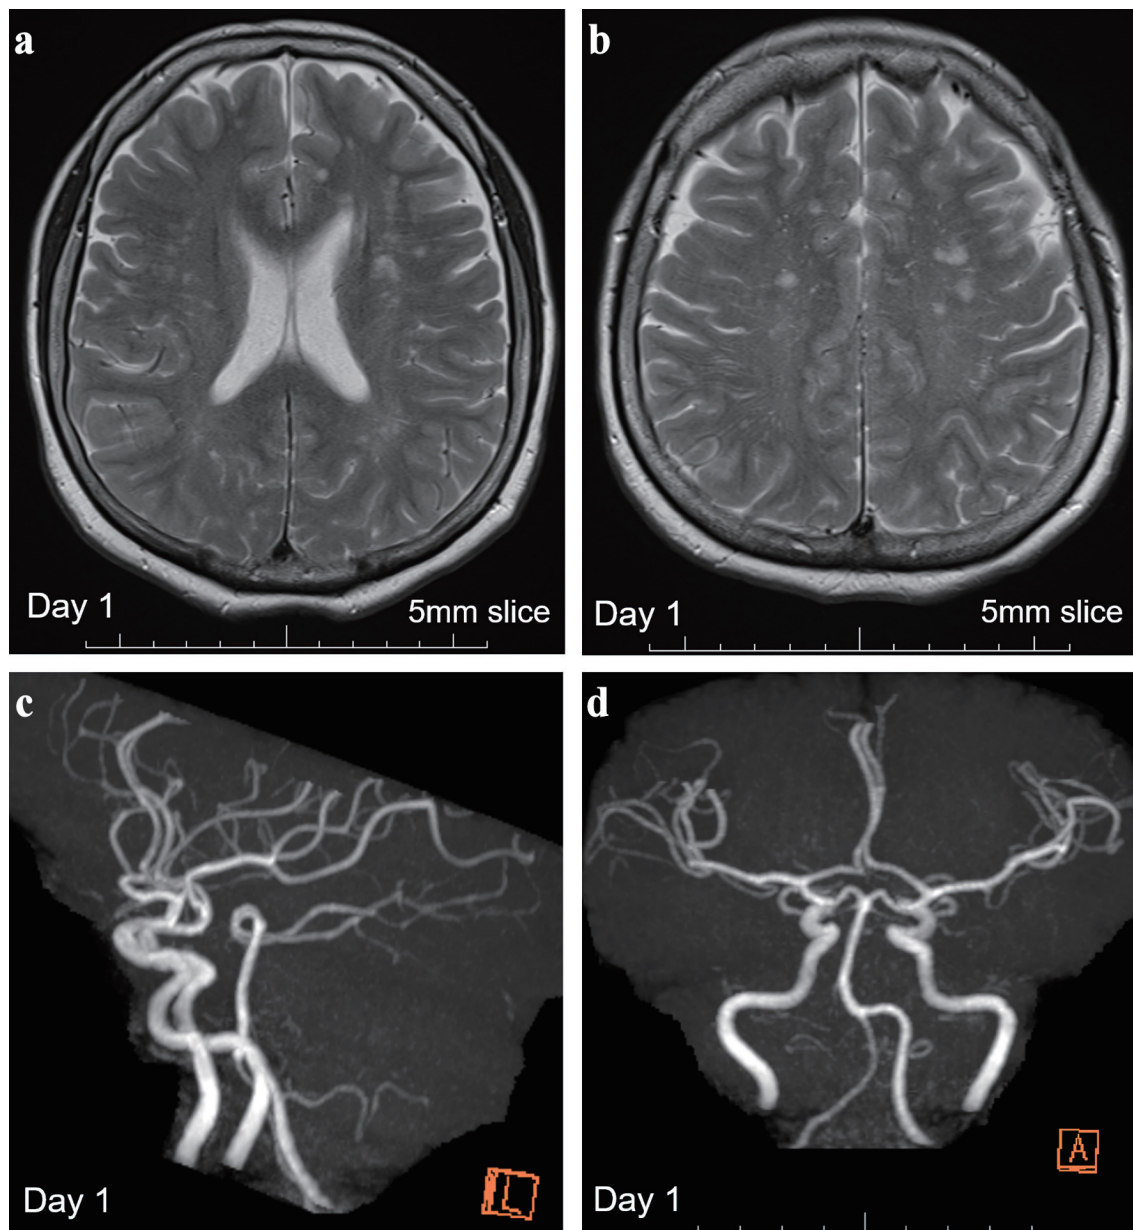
Brain MRI showing multiple old ischemic changes and MR angiography on day 1. (a, b) T2-weighted images with 5-mm-thick brain MRI on day 1 revealed multiple old ischemic changes in both hemispheres. (c, d) Normal MR angiography findings with a patent posterior circulation system. MRI: magnetic resonance imaging; MR: magnetic resonance.
